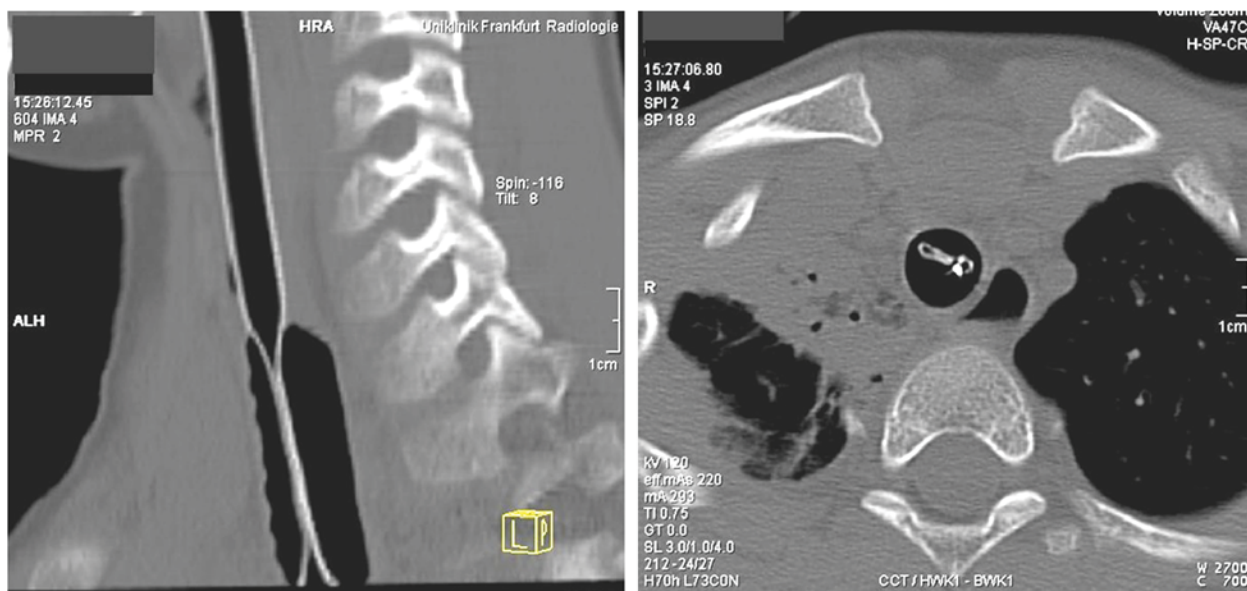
External compression of endotracheal tube. Computed tomography images of the sagittal plane of the cervical spine and trachea (*left panel*) and transversal plane at the level of the first thoracic vertebra (*right panel*) in an 8-year-old boy who required endotracheal intubation as a result of multiple injuries received in a traffic accident. The inflated cuff produced critical obstruction of the endotracheal tube. The *white dot* on the scan in the right panel indicates the obstructed lumen of the tracheal tube. (Used, with permission, from Hofstetter et al.¹⁴)
